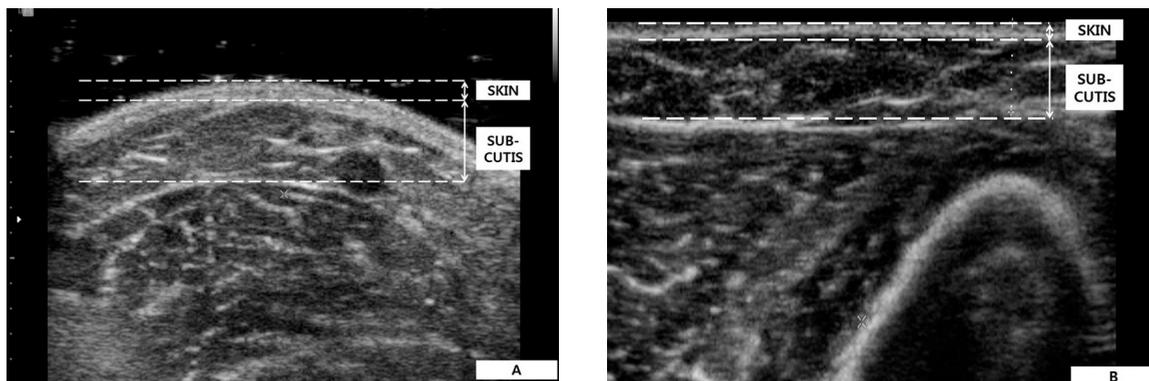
Ultrasonographic images of the arm of a patient with lymphedema demonstrating the thickness of the skin, subcutaneous tissue, and their sum with minimal compression (A) and with maximal compression (B).
